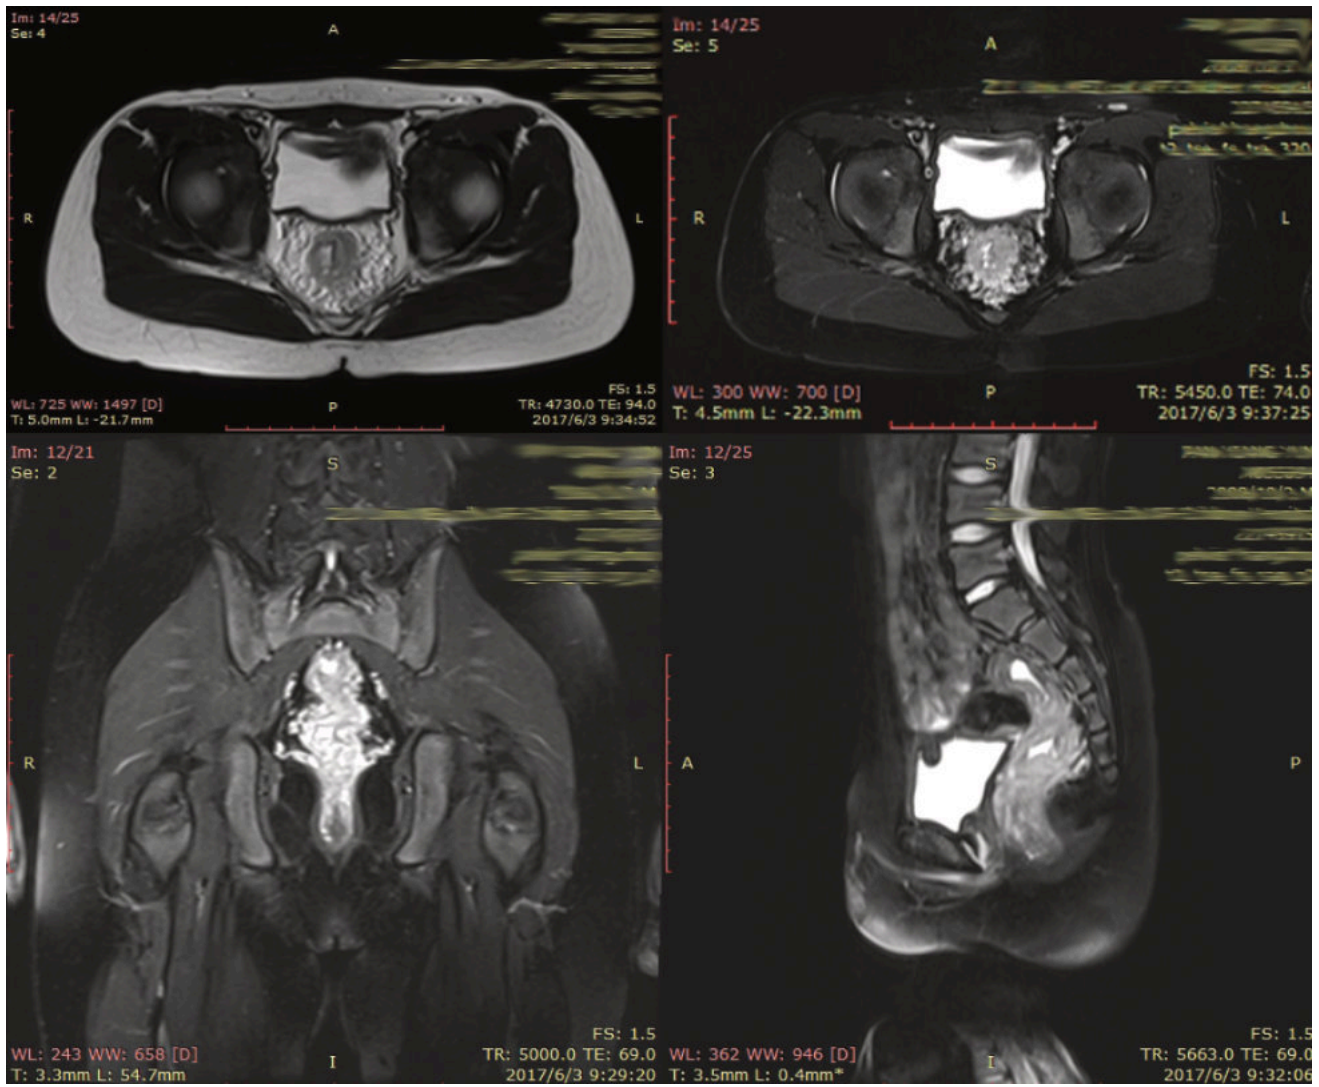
Abdominal MRI showed that the rectal wall was significantly thickened with obvious T1 and T2 signal changes, the inner wall of the rectum was irregular, and the outer side of the rectum was coarse. A thick reticular mass of long T1 and long T2 signals was seen around the rectum. The possibility of rectal wall and perirectal vascular malformations was considered.
